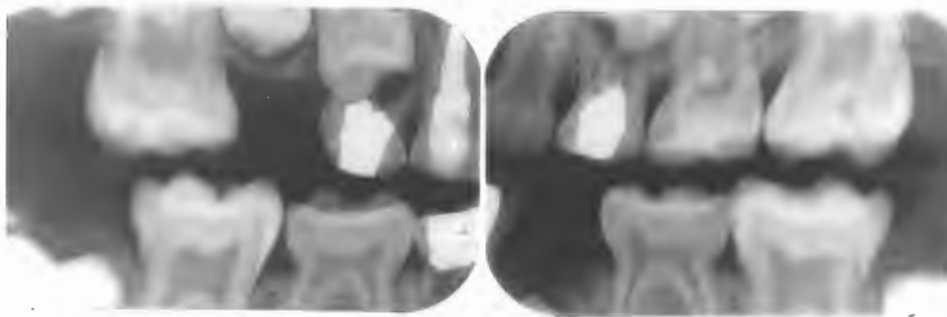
Bite-wing radiographs of Case 1 taken at age 10 years.
